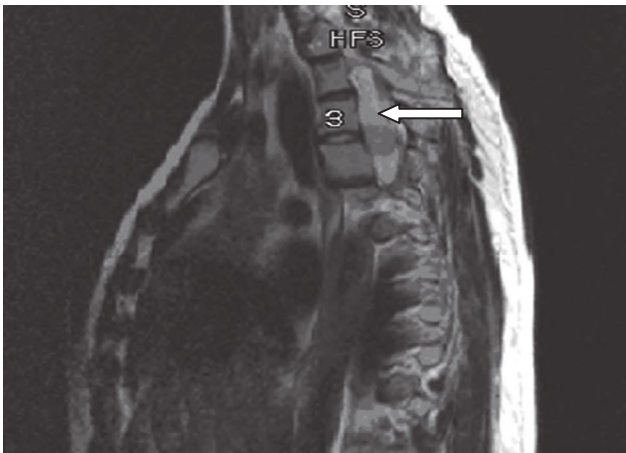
MRI of the thoracolumbar spine, T1 weighted image taken in 2004, showing a well-defined enhancing nodule in the spinal cord at the level of T3-T4 with intermediate signal intensity.
